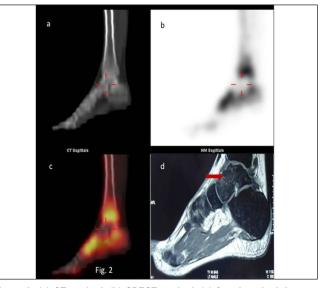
(a) CT sagittal, (b) SPECT sagittal, (c) fused sagittal, images showing the photopenic area corresponding to the left talus on the fused CT images (triangulation) suggesting AVN. (d) MRI sagittal images showing marrow signal abnormality (red arrow)
